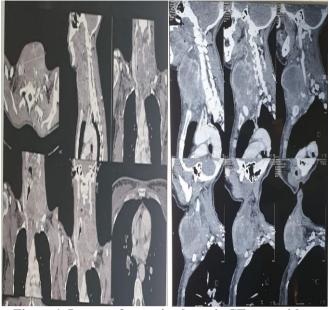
Images of a cervicothoracic CT scan with an injection of contrast product in axial coronal and sagittal slice showing a cervical mass depending on the left thyroid compartment with homolateral internal jugular vein thrombosis and right pulmonary embolism
